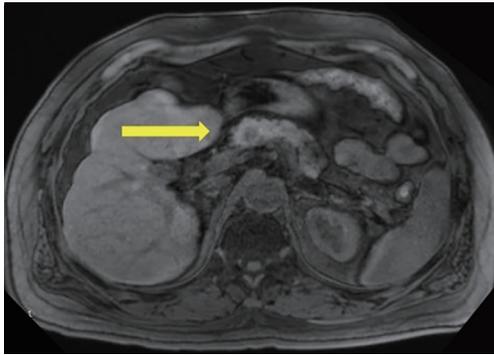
Clinical case 1: MRI with evidence of pancreatic insulinoma.
